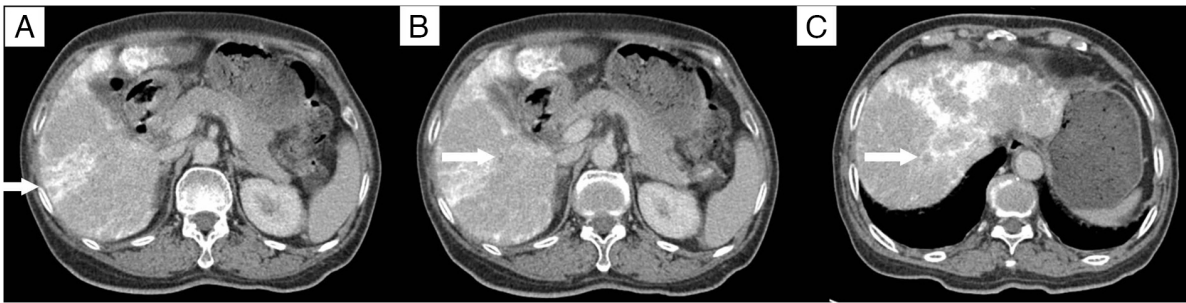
Enhanced computed tomography scans following transarterial chemoembolization. (A) The lesion beneath the liver capsule in the right lobe shows no significant reduction in size compared with before, with mild enhancement (arrow). (B) The lesion adjacent to the portal vein in the right lobe still shows mild enhancement (arrow). (C) The lesion at the apex of the right lobe of the liver shows no significant reduction in size compared with before, with mild enhancement (arrow).
